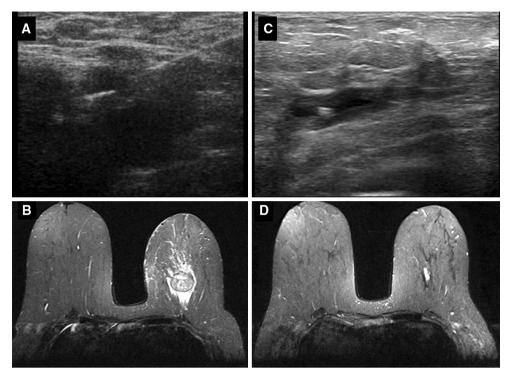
a Placement of hydrogel-encapsulated clip at time of initial US-guided biopsy. b Pre-neoadjuvant chemotherapy T2 weighted MRI image of clip within mass. c US image of clip at time of surgical
